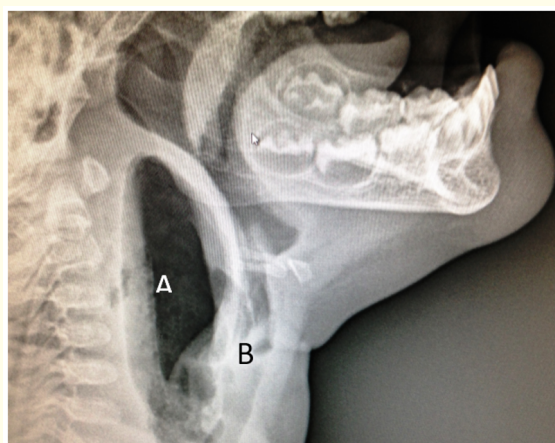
Lateral cervical radiograph showing the following findings: A. Large esophageal retro cyst in relation to vertebrae C1 and T1; B. Anterior displacement of the trachea with consequent esophageal compression.
